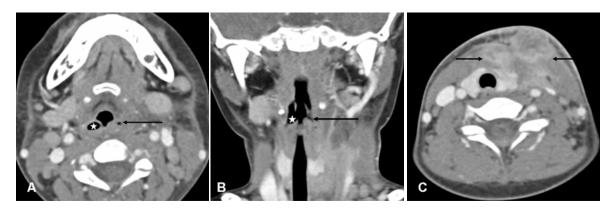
A, B: Axial (A) and coronal (B) CT shows deformity of the left pyriform fossa (arrow) by the adjacent soft tissue swelling, compared to the right pyriform side (white star). C: Axial CT (lower level from A) shows multilobulated hypoattenuation mass in left perithyroid region (arrows) with slightly decreased high density of the left thyroid lobe
